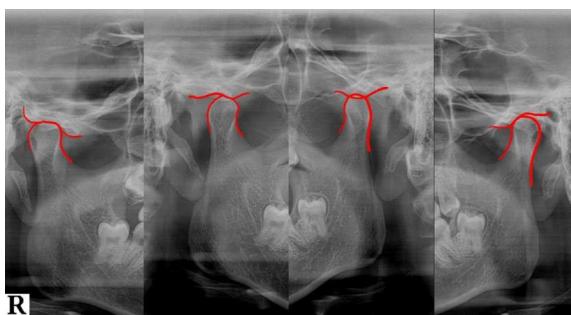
Temporomandibular joint radiograph
